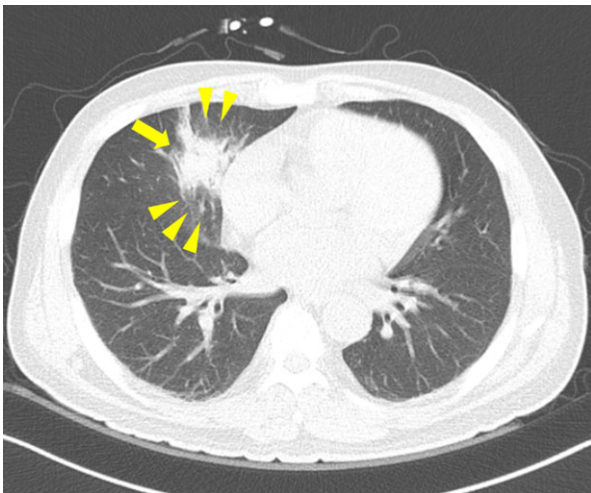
Low dose computed tomography of the lung. Consolidation with surrounding ground glass opacity at the medial segment of the right middle lobe.
